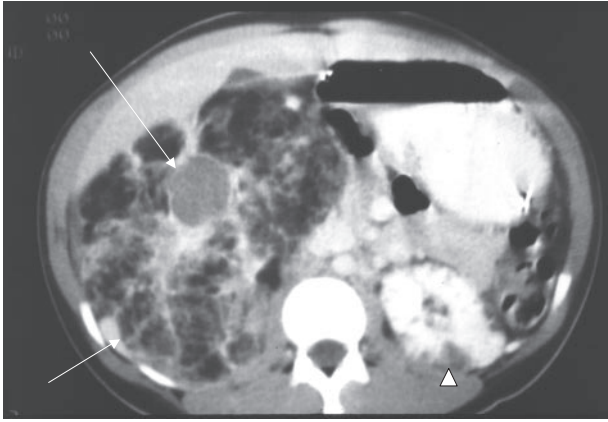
Abdominal CT scan of an angiomyolipoma; abdominal CT scan of a LAM patient with a very large angiomyolipoma. Note the diffuse involvement and massive enlargement of the right kidney (arrows). The combination of solid and fat density within the lesion is characteristic of angiomyolipomas. The left kidney has a small angiomyolipoma on the inferior margin (arrowhead).
